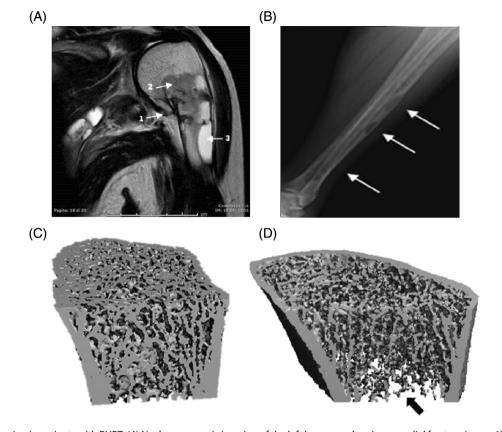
Skeletal imaging in patients with PHPT. (*A*) Nuclear magnetic imaging of the left humerus, showing a medial fracture (arrow 1) and a brown tumor with solid (arrow 2) and liquid (T2-weighted image, arrow 3) components. (*B*) Radiograph of the left leg, showing cortical thinning and multiple lytic lesions (arrows) in tibia and fibula. (*C*,*D*) Representative HRpQCT images of the 1/3 distal radius of PHPT (*D*) and control (*C*) subjects. In PHPT (*D*), total vBMD is reduced (340.3 versus 771.4 mg HA/cm³), cortical thickness is reduced (0.56 versus 0.7 mm), with a decrease in trabecular density (101 versus 179.2 mg HA/cm³), number (1.64 versus 1.72 1/mm), and increase in trabecular separation (0.557 versus 0.494 mm) (arrow). Figure modified from Stein and colleagues.⁽⁸³⁾ HA = hydroxyapatite.
